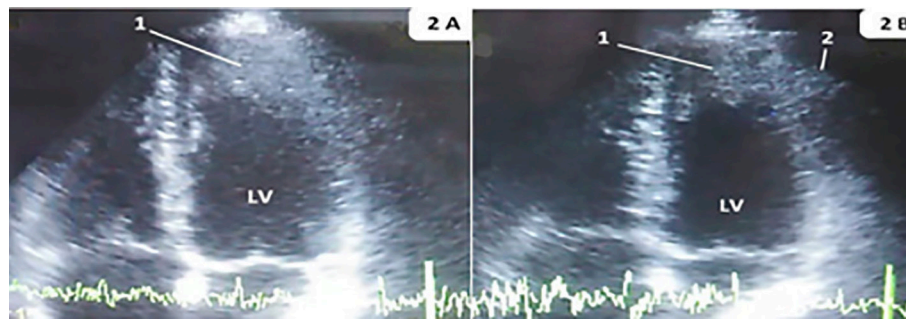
Apical 4-chamber view during stress-EchoCG test: 2A – before the test; 2B – after stage 2 (1 – the local effect of spontaneous contrasting; 2 – the part of the thrombus beyond the pericardium).
